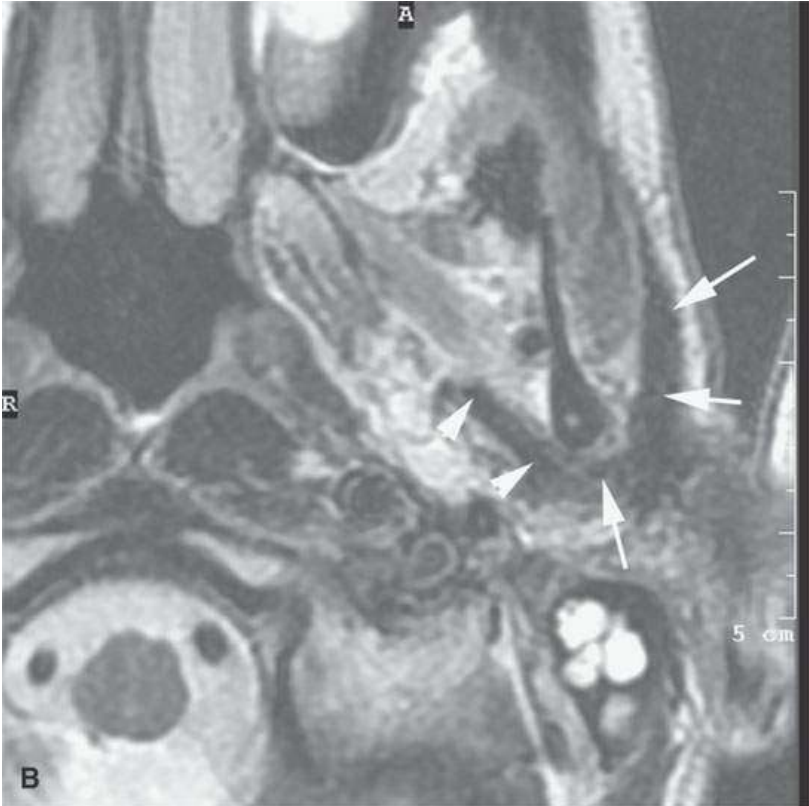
Contrast-enhanced magnetic resonance of a patient treated with surgery and radiotherapy for parotid cancer. A: Non-contrast-enhanced T1-weighted (T1W) image shows mainly a band of scar (*arrows*), but notice how the more medial component (*arrowheads*) enhances markedly in (cC). B: T2-weighted image shows mainly a band of scar as less intense than muscle (*arrows*), but notice how the more medial component (*arrowheads*) enhances markedly in (cC). C: Contrast-enhanced T1W images shows minimal if any enhancement of the scar seen as end-stage fibrosis in all images (*arrows*); however, the medial component enhances (*arrow heads*) and was proven to be local and perineural recurrence spreading back to trigeminal ganglion (not pictured).
